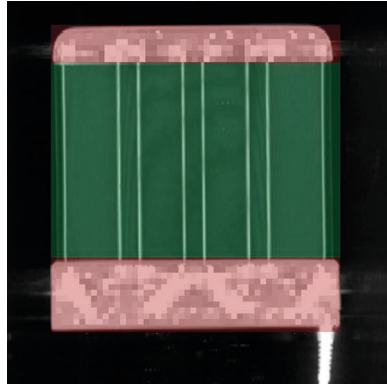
CT projection image (MIP) of an MR-linac receive array. The radiolucent window (green) is approximately 30 cm high and contains no electronics, except conductors for signal reception. All electronics are moved to the feet and head sides (red). Image from Hoogcarspel et al. (2018). Reproduced by permission of IOP Publishing.
